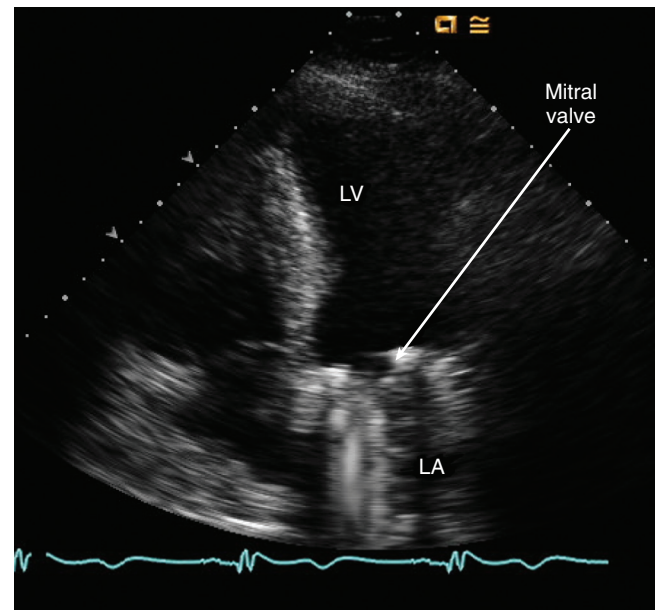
■ Apical four-chamber view in a patient with a mechanical mitral valve. Acoustic shadowing distal to the valve obscures visualization of the left atrium (LA). LV, Left ventricle.
